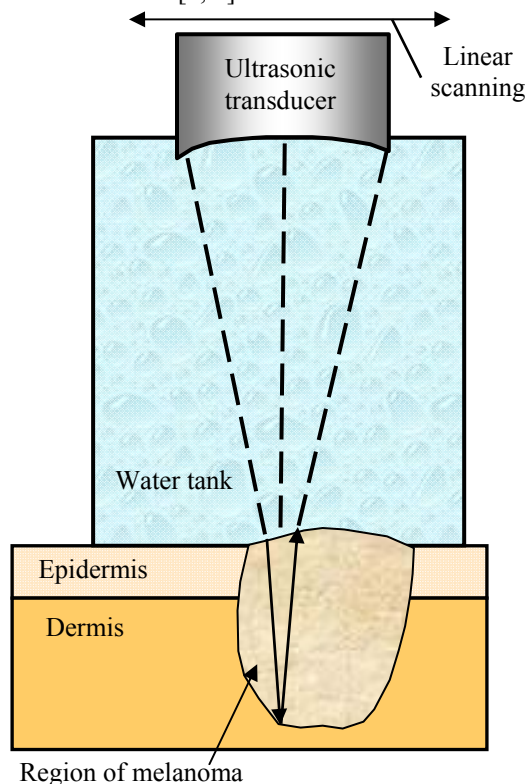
Principle of skin assessment using pulse-echo ultrasonic technique
